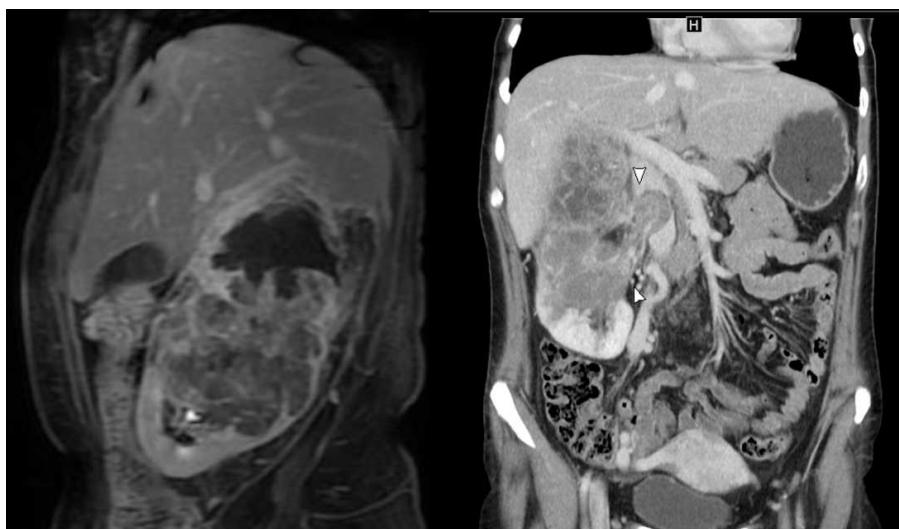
Sagittal T1-weighted MRI with intravenous contrast showed a large renal mass with evident tumor necrosis.
